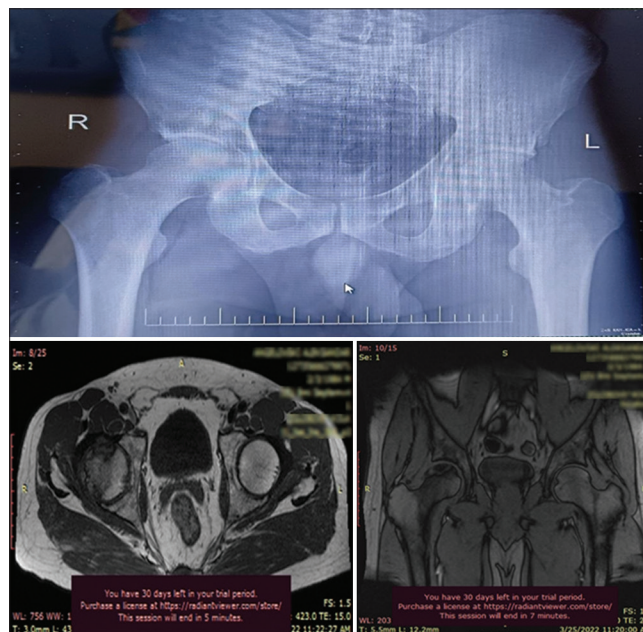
Anteroposterior radiograph and MRI of the 37-year-old male patient confirming avascular necrosis of the right femoral head (Ficat–Arlet stage III)
